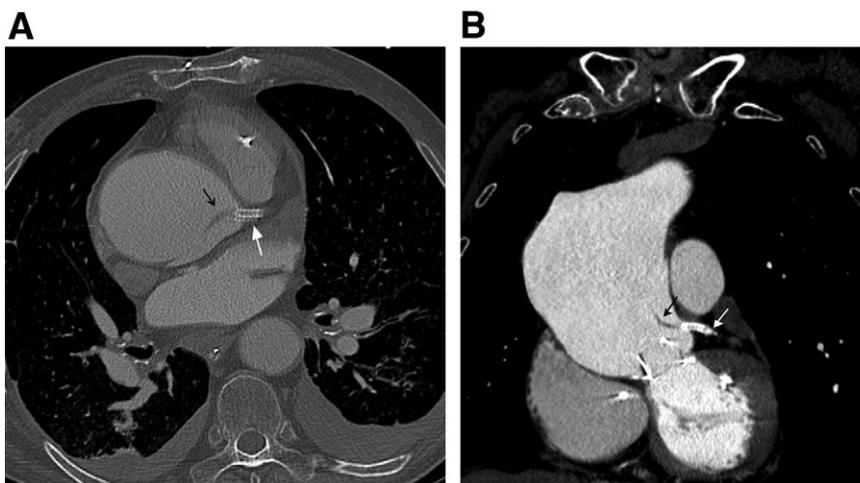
CT of the Ascending Aorta After Stent Placement at the Ostium of the LM
